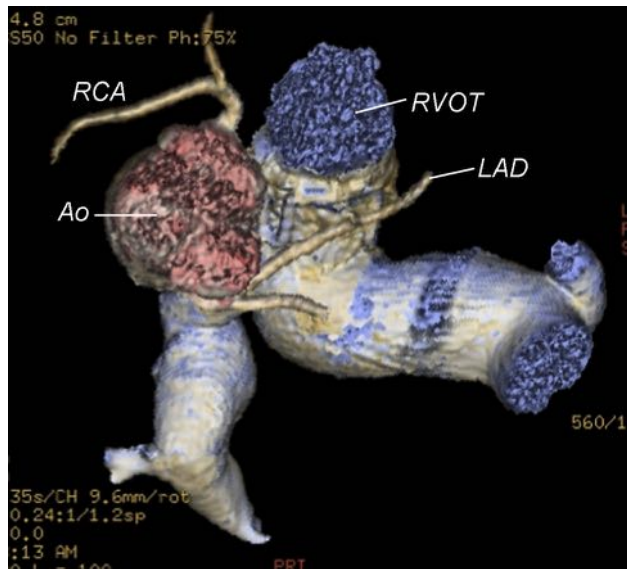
Computed tomographic 3D reconstruction demonstrating coronary artery anatomy in a patient with repaired TOF. Ao, Aorta; LAD, left anterior descending coronary artery; RCA, right coronary artery.
